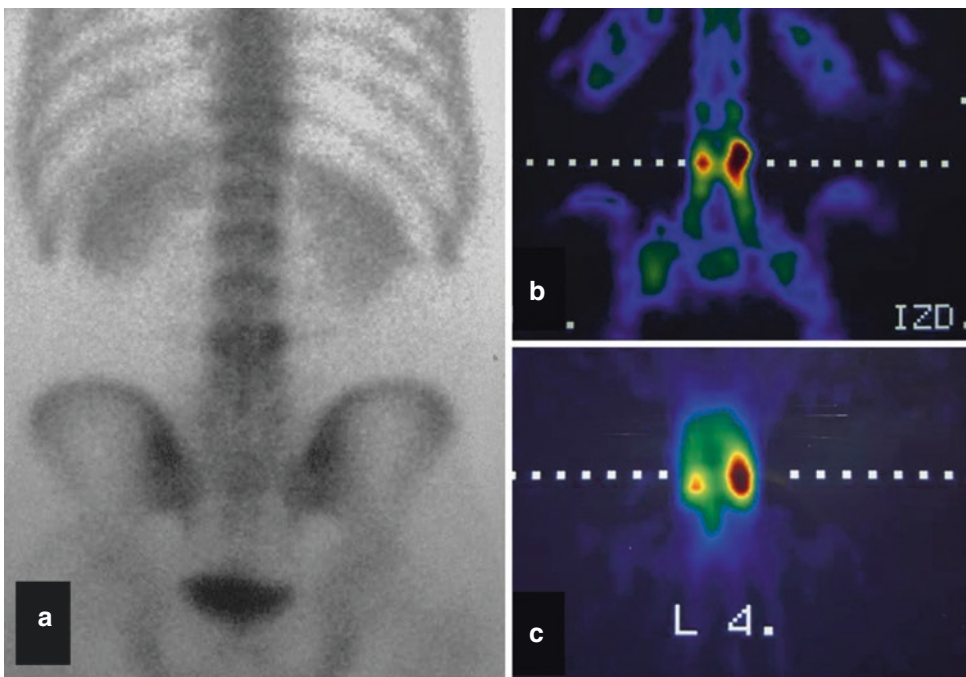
(a) Planar bone scintigraphy image with increased uptake of the left L4 spinal bone comparing with right. SPECT bone examination coronal (b) and axial (c) image with the same increased uptake
